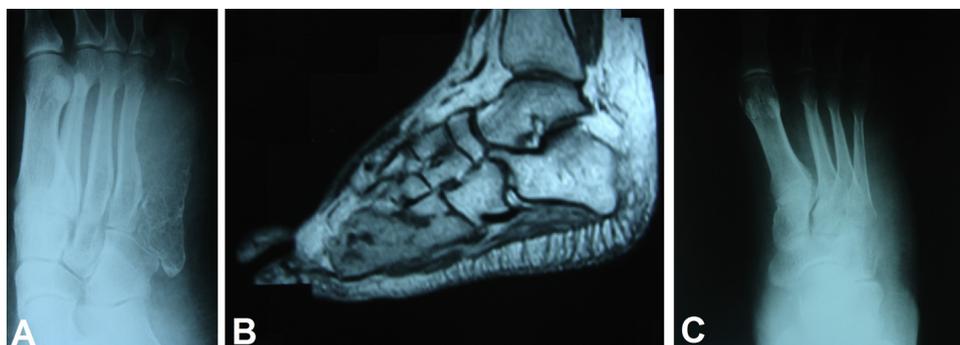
A case of female patient 34 years old with giant cell tumor of the 5th metatarsal bone. A) Preoperative plain X-ray showing complete wash out of the 5th metatarsal bone. B) Preoperative MRI, sagittal view. C) Three-months postoperative X-ray after resection of the tumor with the 5th ray showing no recurrence.
